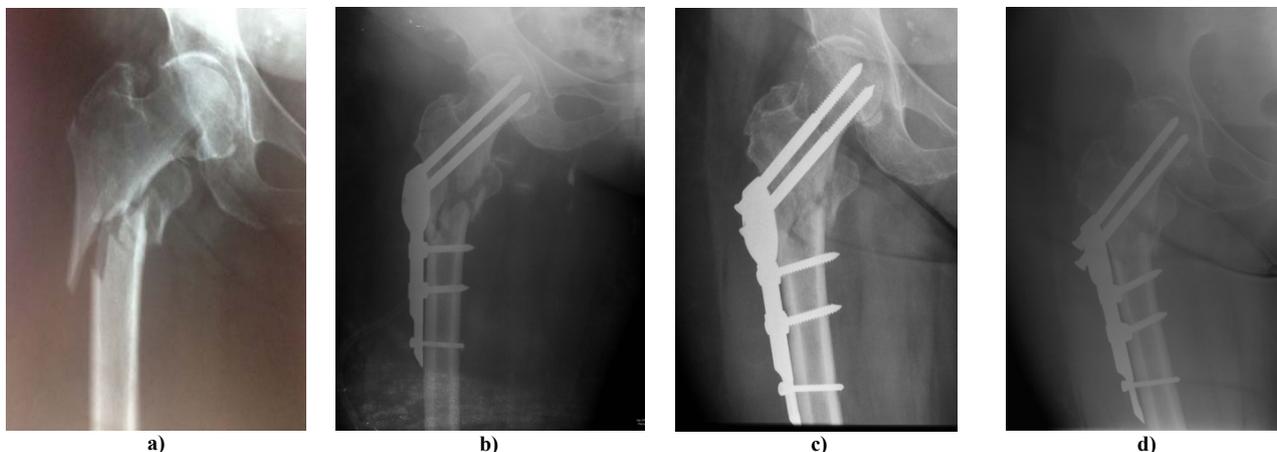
Radiographs of a 63-year-old-female patient with unstable, reverse obliquity, intertrochanteric fracture (AO type 31-A3.3).
